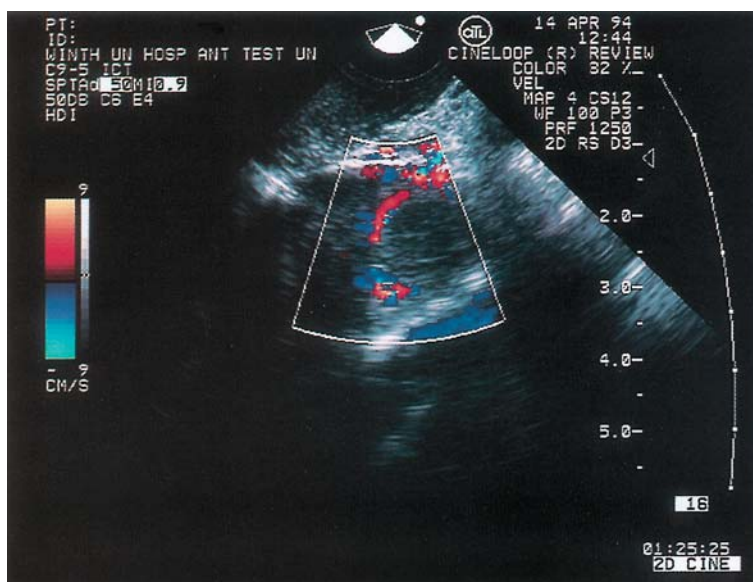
Hyperstimulated right ovary. Color Doppler velocimetry shows the intraovarian blood flow
